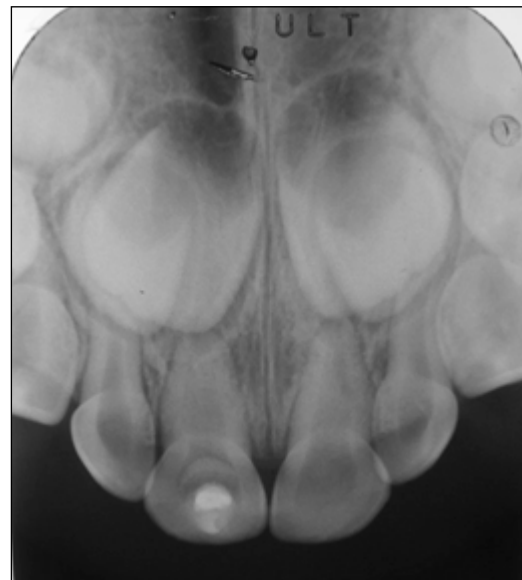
Radiographic image at 2 years follow-up
